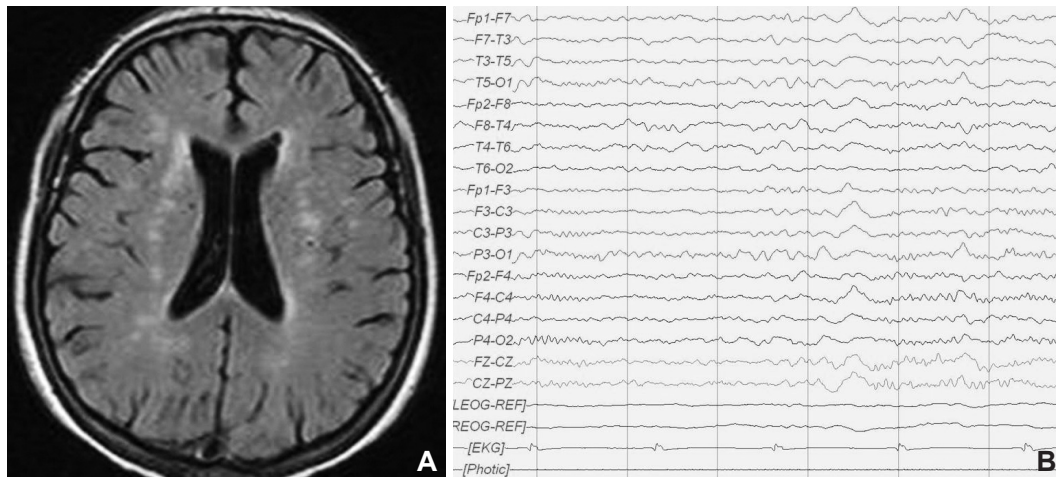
An acute infarction was not noted on the brain MRI (A) and an electroencephalography was normal (B).
